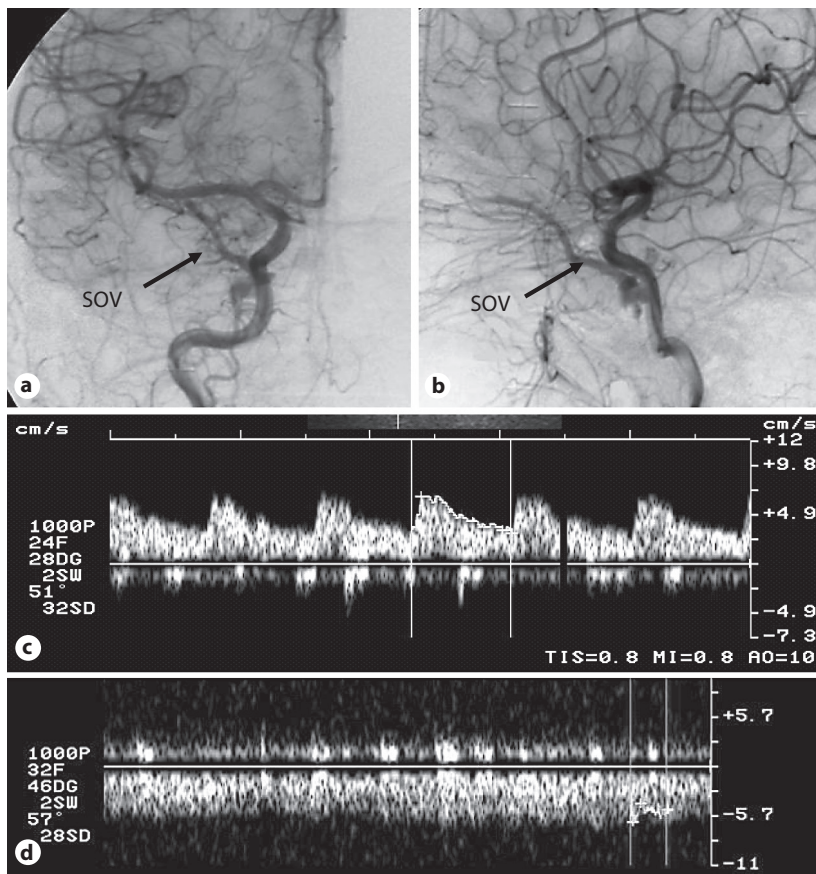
Color Doppler ultrasound can be used to assess flow patterns of CS DAVF before and after treatment. A case of indirect DAVF at the right cavernous sinus with engorged superior ophthalmic vein (SOV) showing on AP (a) and lateral views (b) of the common carotid angiogram. (c) Color Doppler ultrasonography revealed pulsatile reverse flow of the SOV before radiosurgery. (d) Eight months after the treatment, the flow of the SOV returned to normal.
